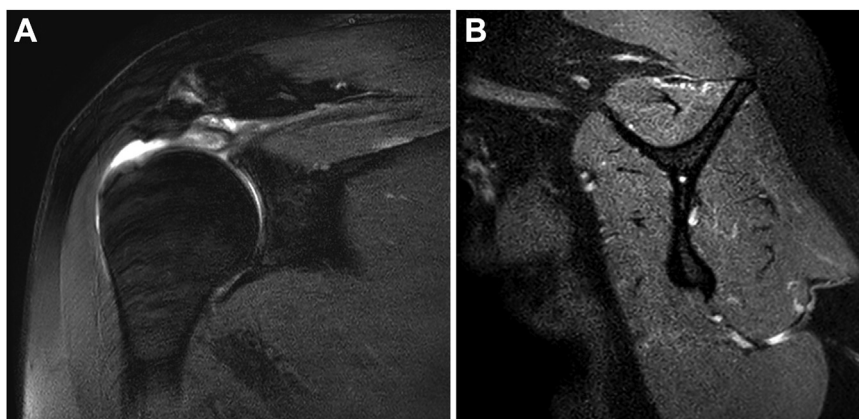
Arthro-MRI (coronal (A); parasagittal (B) plane) T2-weighted, preoperative. *Arthro-MRI*, magnetic resonance arthrography.
